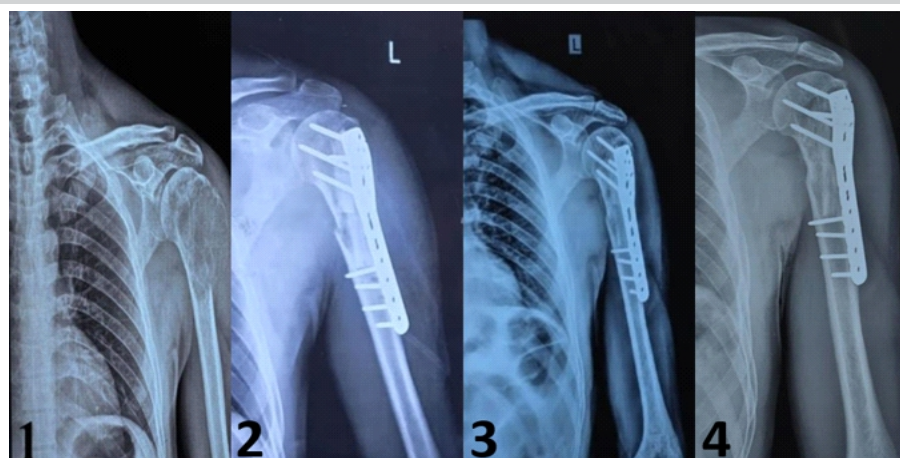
Radiographic findings. (1) Initial X-ray, (2) immediate post-operative, (3) after 1.5 years, (4) after 2 years.
